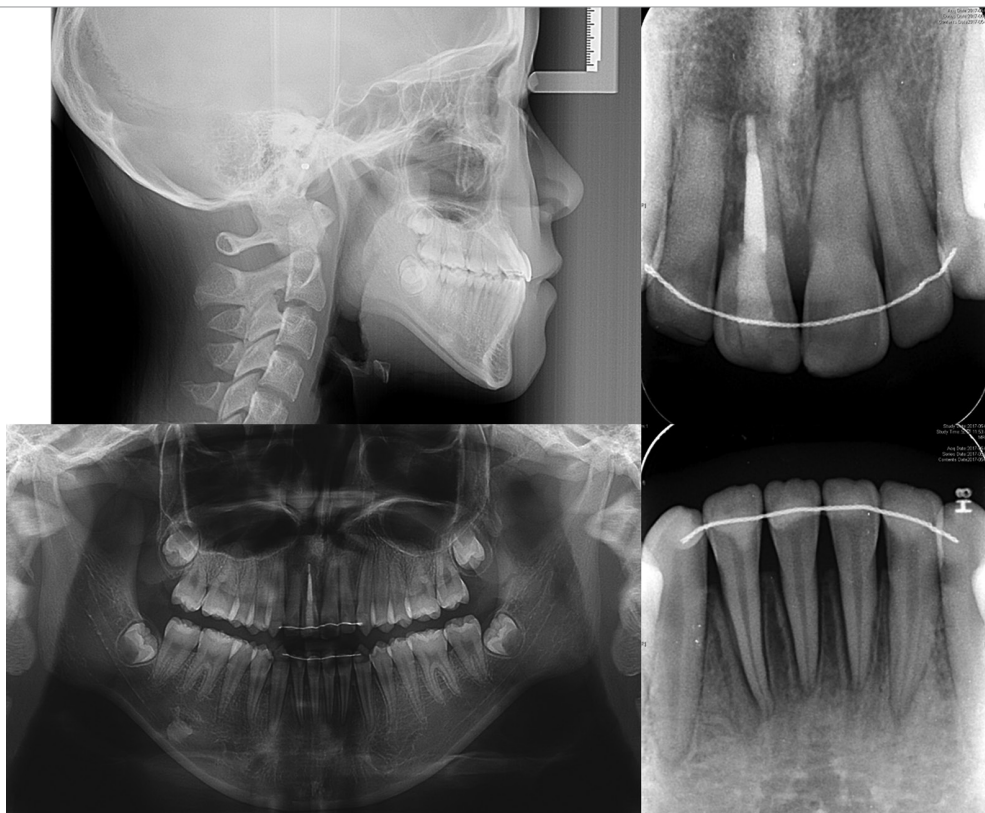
Post-treatment radiographs
